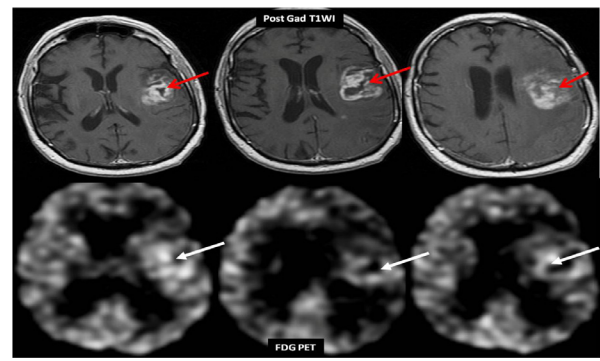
False Positive FDG PET. Panel of Axial Post-Contrast T1 MR Images (Top) and Corresponding FDG-PET Images (Bottom) Show Hypermetabolism (Arrows) in the Area with Corresponding Enhancement. This was a Case of Enhancing Non-Neoplastic Tissue
